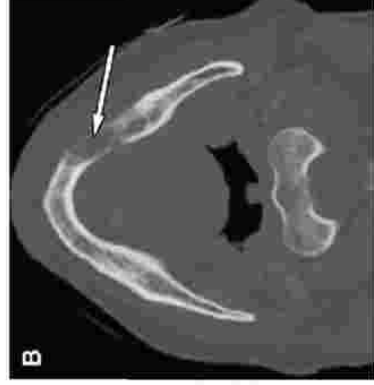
(A) CT scan of the oral cavity showing early invasion of the mandibular cortex from a lower alveolar ridge SCC. (B) CT scan of the oral cavity with gross invasion of the mandible from gingival SCC.
